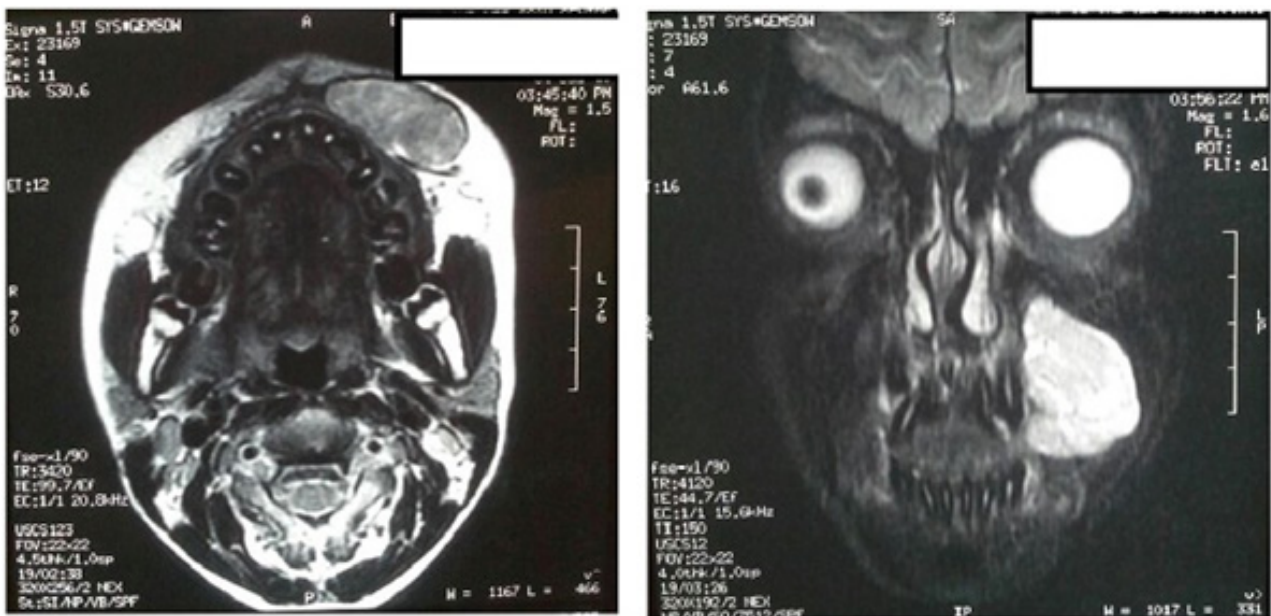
Magnetic resonance imaging (axial and coronal views)
